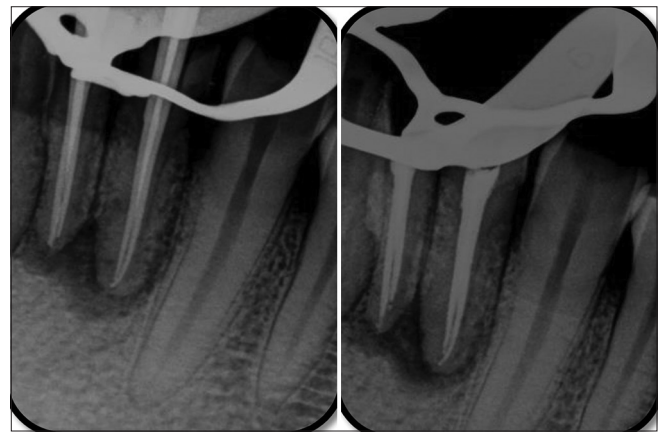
Master cone and obturation intraoral periapical
